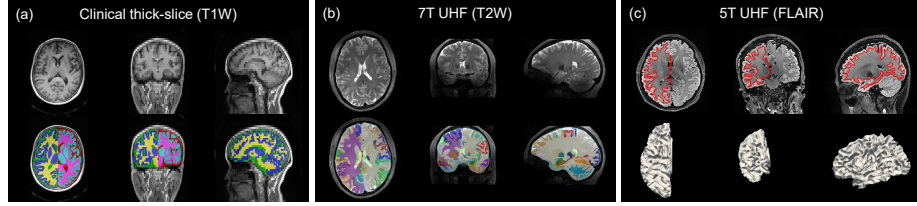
Qualitative evaluation of uBrain on (a) hemisphere tissue segmentation from a clinical thick-slice T1W scan (5 mm thickness), (b) ROI parcellation from a 7T UHF T2W scan, and (c) left WM surface reconstruction from a 5T UHF FLAIR scan.
